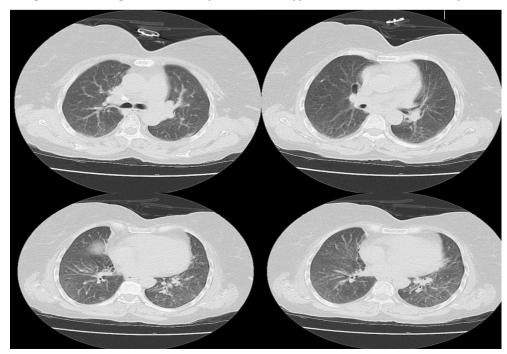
A chest CT showed ground glass opacities with consolidation spots in the middle and upper regions of both lungs
